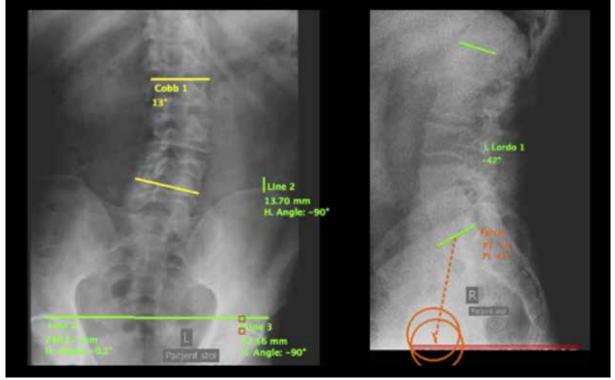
Lumbar spine – lateral and AP radiographs before treatment.
